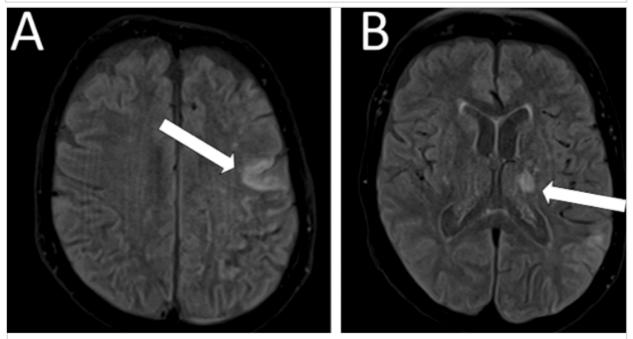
1.5T brain MRI with FLAIR sequences showing a hyperintense signal in the left frontal cortex (part A, arrow) and the thalamic region (part B, arrow).
